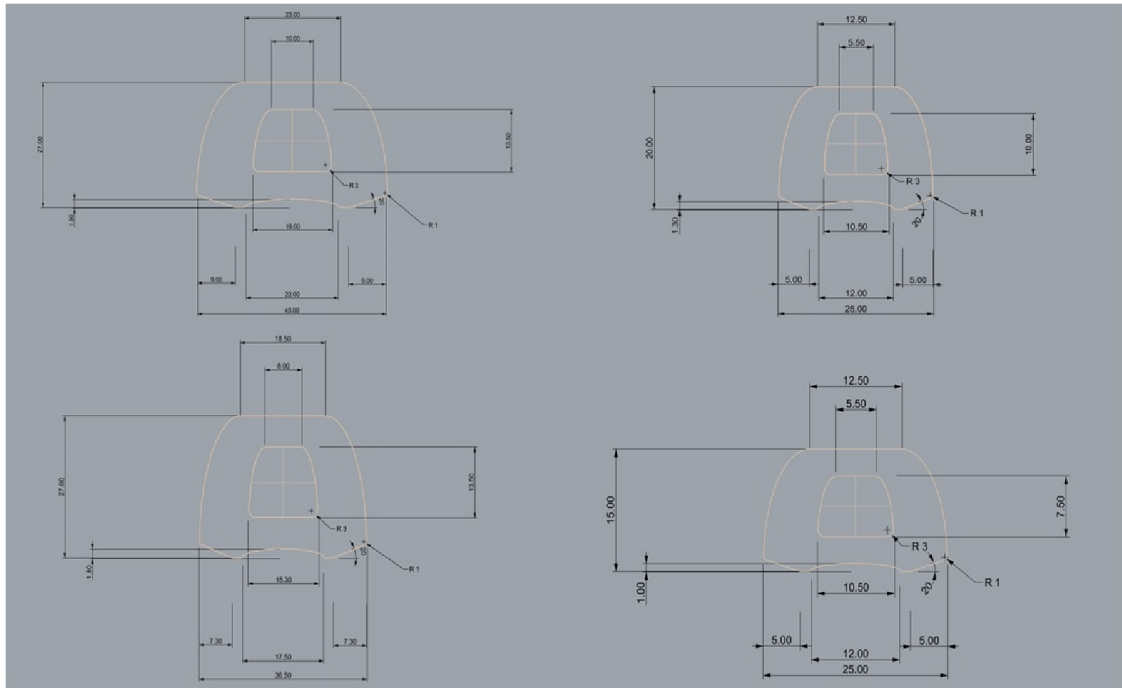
sizes takes from CT images
